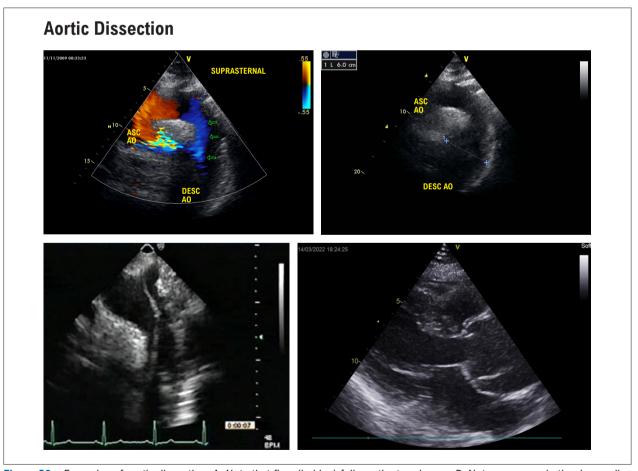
Examples of aortic dissection. A: Note that flow (in blue) follows the true lumen. B: Note aneurysm in the descending aorta. C: visible dissection line. D: dissection and aneurysm in the ascending aorta seen on parasternal long-axis view. ASC AO: ascending aorta; DESC AO: descending aorta.
